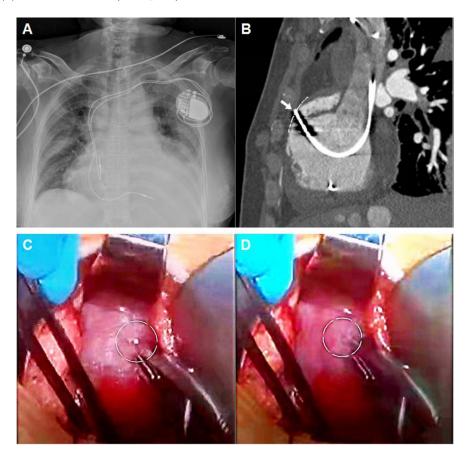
(A) Chest X-ray revealing the enlarged cardiac shadow, with the leads located within the range of the cardiac shadow. (B) CTA with sagittal multiplanar reconstruction showing the tip of the atrial lead displaced forward (arrow) and slightly beyond the edge of the epicardial fat pad (white dashed line). (C) Intraoperative image showing the tip of the atrial lead (in circle) protruded slightly through the atrial wall. (D) The tip of the atrial lead retracted into the atrium.
